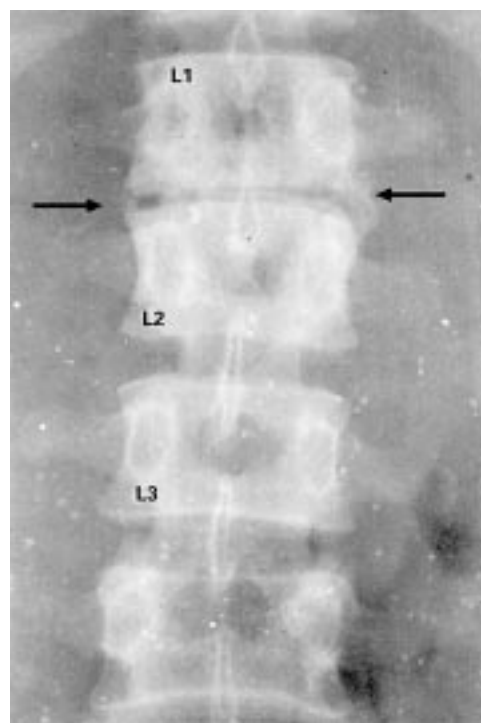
Radiograph of lumbar spine (anteroposterior view). Note narrowing of the L1–L2 space (arrows).
